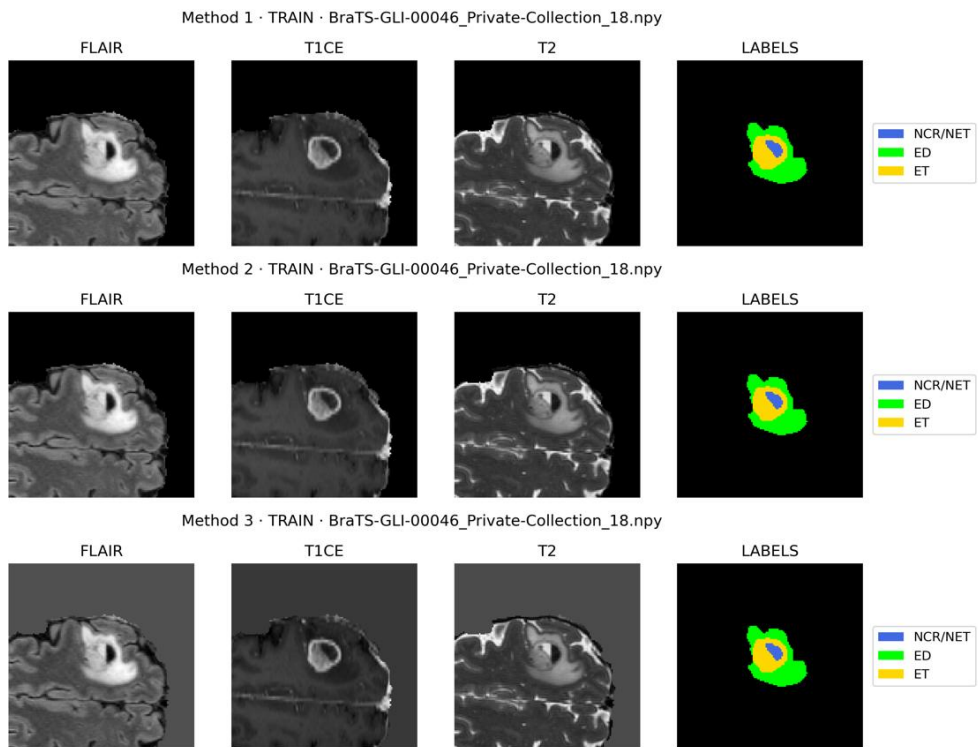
Images from the training set after preprocessing with Methods 1, 2, and 3. Each row shows FLAIR, T1GD, and T2 with the corresponding segmentation labels.
